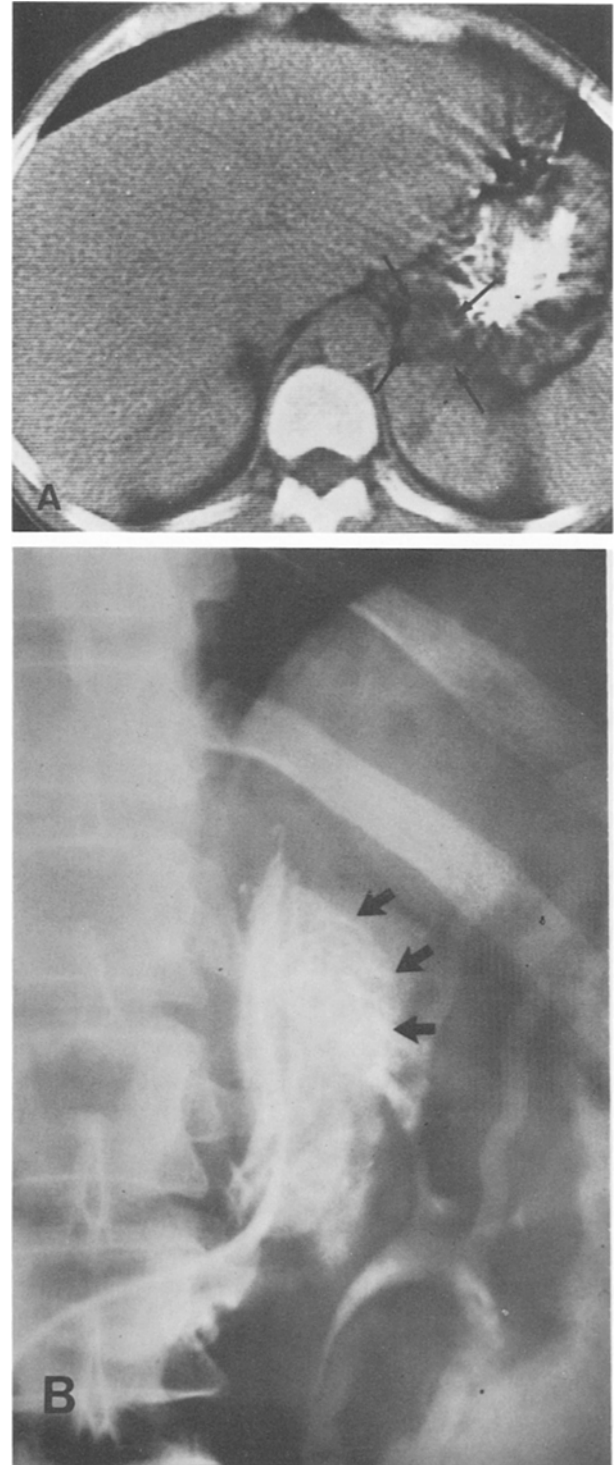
CT scan-demonstrated lesion in left adrenal cortex (A) is confirmed by venous sampling and venogram (B) as the source of this patient's primary aldosteronism.
